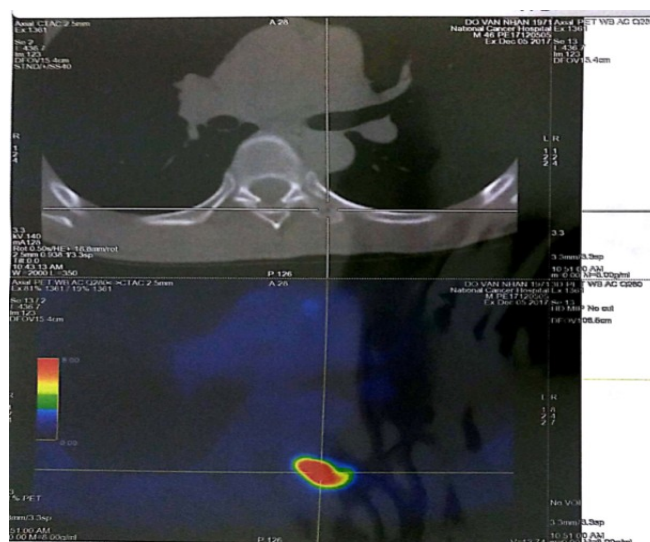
PET/CT scan at 3 months after the completion of chemoradiotherapy
